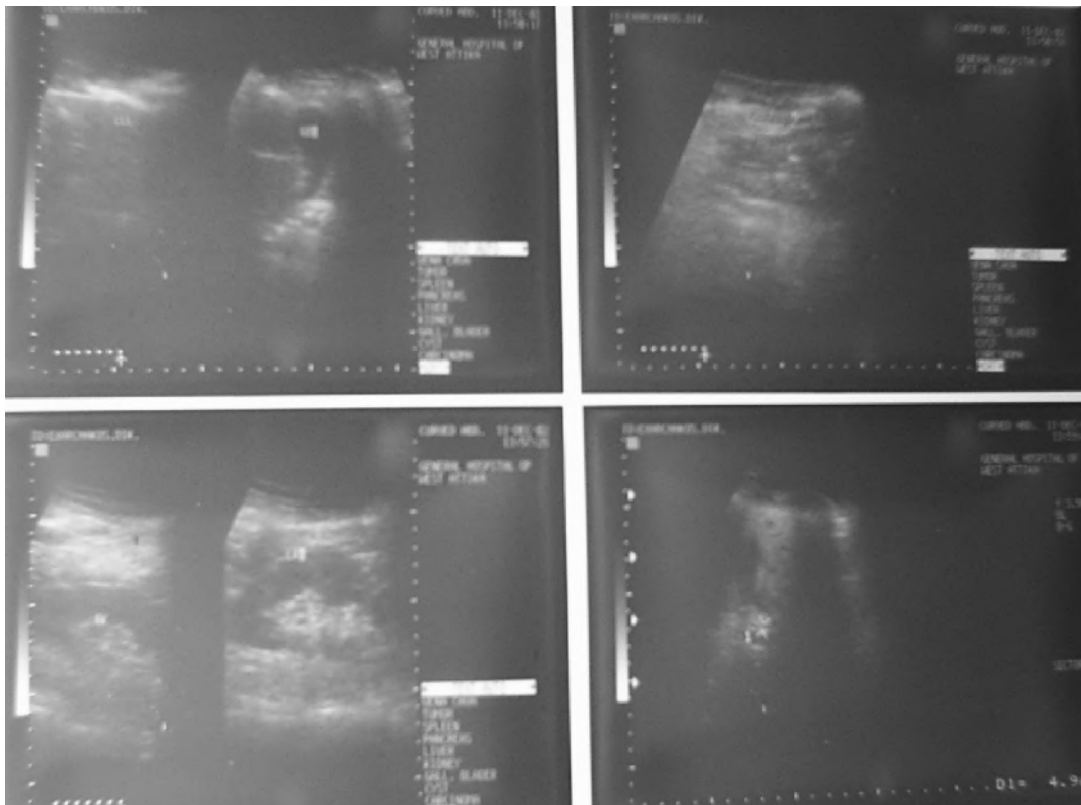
Abdominal ultrasound in which the site of the perforation was revealed (arrow).
